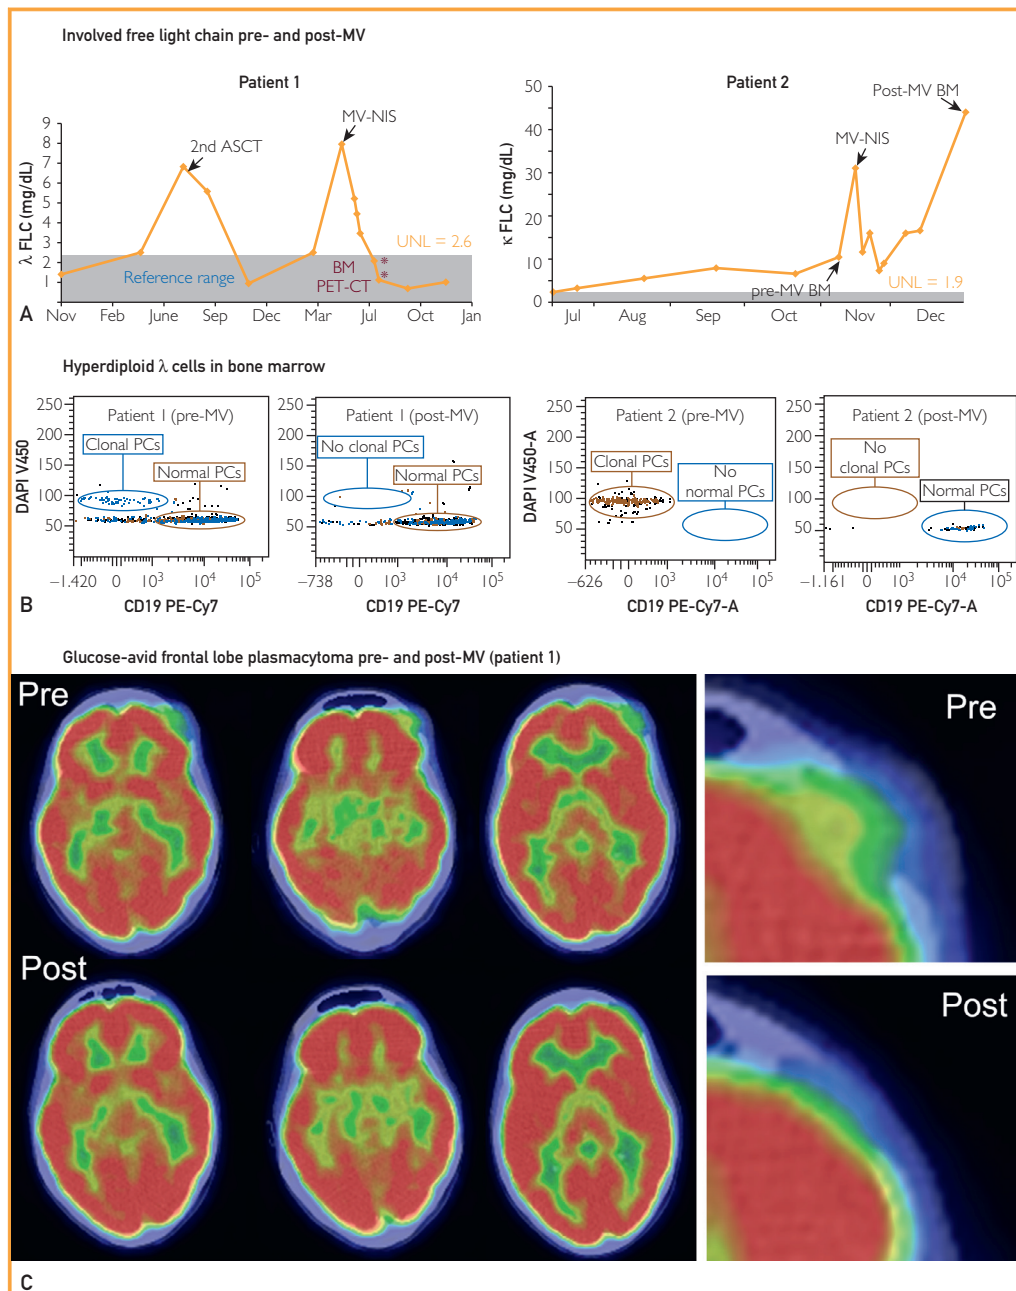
Clinical response to systemically administered MV-NIS. A, Serial free light chain (FLC) measurements in patients 1 and 2 as a surrogate of myeloma tumor burden, increasing at myeloma relapse and decreasing after successful therapy. Asterisks indicate the timing of relevant bone marrow (BM) and positron emission tomography—computed tomography (PET-CT) examinations. B, High-sensitivity 8-color plasma cell (PC) flow cytometry performed on pretherapy BM samples from both patients (left panels) shows CD38- and CD138-positive, CD19-negative monoclonal PCs (λ -restricted in patient 1, κ -restricted in patient 2) with hyperdiploid DNA content. In these same studies performed on BM samples obtained 6 weeks after therapy (right panels), the abnormal PCs are not present. C, Alternate coronal PET-CT sections at the level of the left frontal plasmacytoma in patient 1 before and 7 weeks after MV-NIS therapy. Far right panel shows higher magnification of the middle sections, focusing on the plasmacytoma. Note the pretherapy cerebral compression and altered skin contour that normalize after therapy. ASCT = autologous stem cell transplant; DAPI = 4',6'-diamidino-2-phenylindole; MV = measles virus; UNL = upper normal limit.
